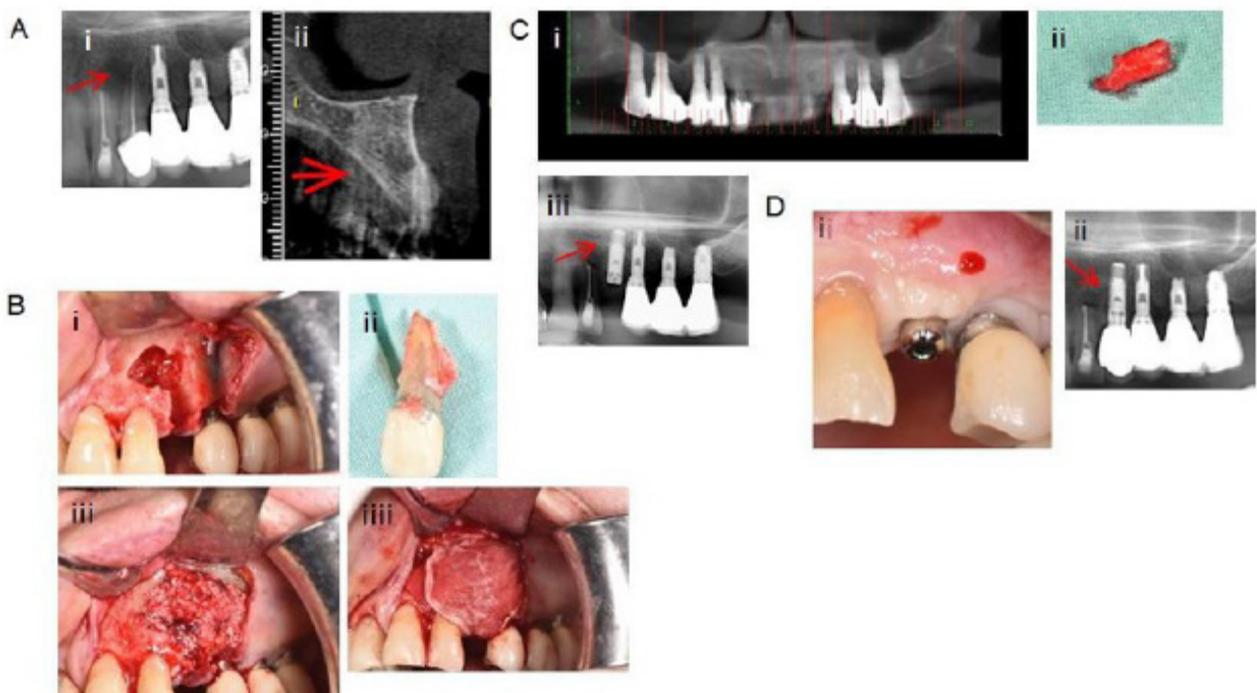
Work flow of augmentation procedure. A) The diagnostic stage: panoramic view (i) and CT section (ii) showing the bone defect. Arrows indicate areas with resorbed bone. B) First stage of procedure: the extracted tooth and socket after debridement (i), ridge preservation procedure: the bone defect was filled with Bio-Oss[®] mixed with Metronidazole and PRP (iii) covered with PPP (iiii). C) Second stage of procedure: CT of the filled socket 5 months after ridge preservation (i), bone sample of the augmented bone (ii), and X-ray of the implant after position at the site from which the bone sample was taken (iii). D) Implant exposure after 6 months, showing placement of the prosthetic (i) and X-ray of implant 1.5 years post rehabilitation (ii). Arrows indicate the implant site.
